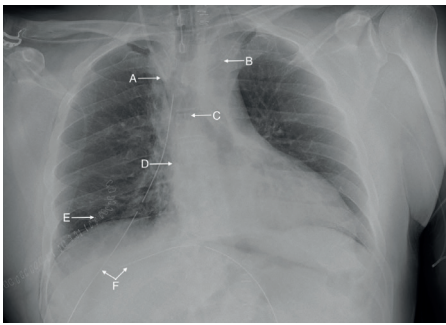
The ideal position of a central venous catheter in the internal jugular vein on a chest X-ray. A: central venous catheter; B: peripherally inserted central catheter; C: carina; D: right atrium; E: surgical staples; F: chest drains.
